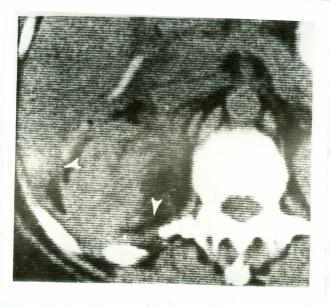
Perirenal abscess. Precontrast CT scan through upper pole of right kidney demonstrates two small air pockets (arrowheads), thickened renal fascia.
